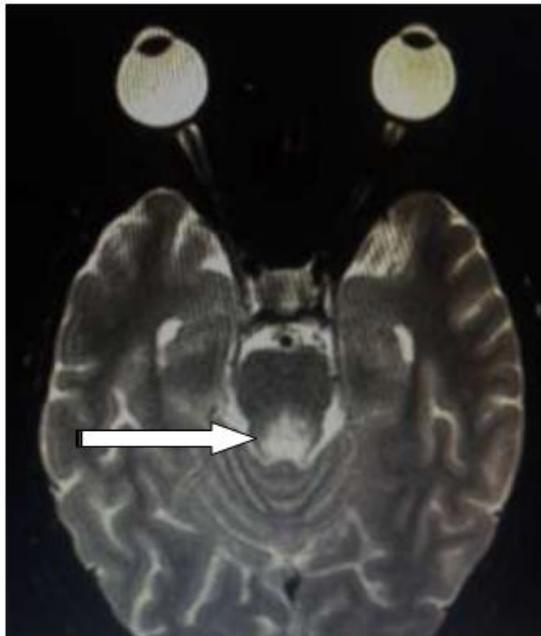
T2W MRI image showing bilateral lesions in dorsum of rostral pons
